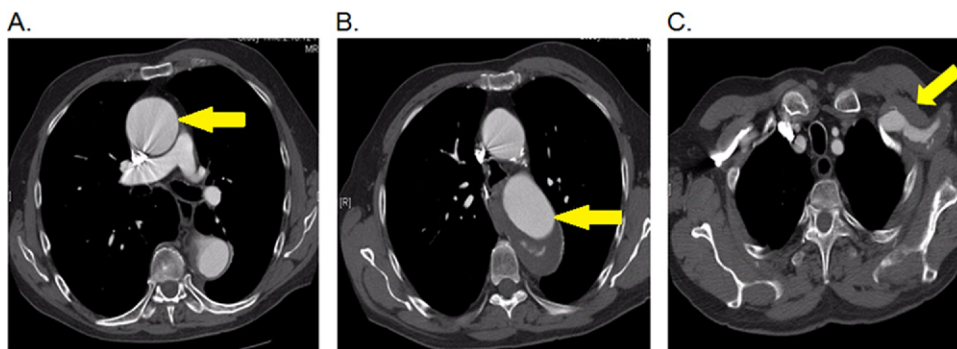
Preoperative computed tomography angiography demonstrating (A) 5.5 cm ascending and transverse aortic arch aneurysm (*arrow*); (B) 6.1-cm Extent II thoracoabdominal aneurysm (*arrow*); and (C) left subclavian artery aneurysm (*arrow*).
